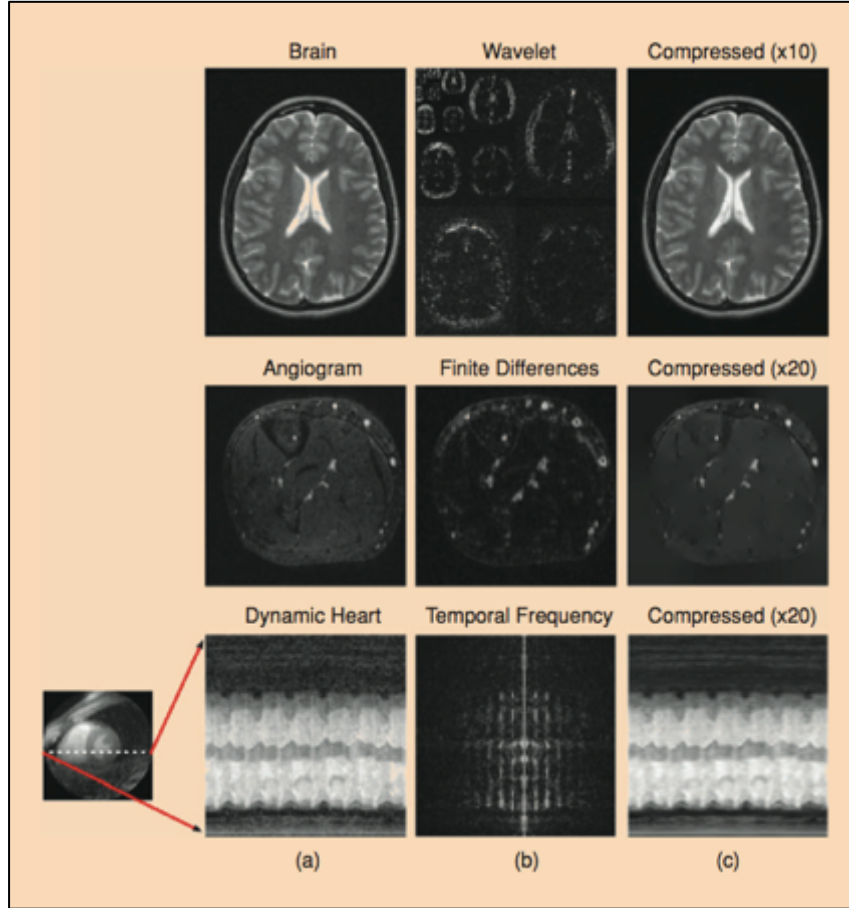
Transform sparsity of MR images. (a) Fully sampled images are mapped by a sparifying transform to a (b) transform domain. The largest coefficients are maintained while the others are set to zero. The transform is then inverted and the reconstructed image (c) is formed.[40]
